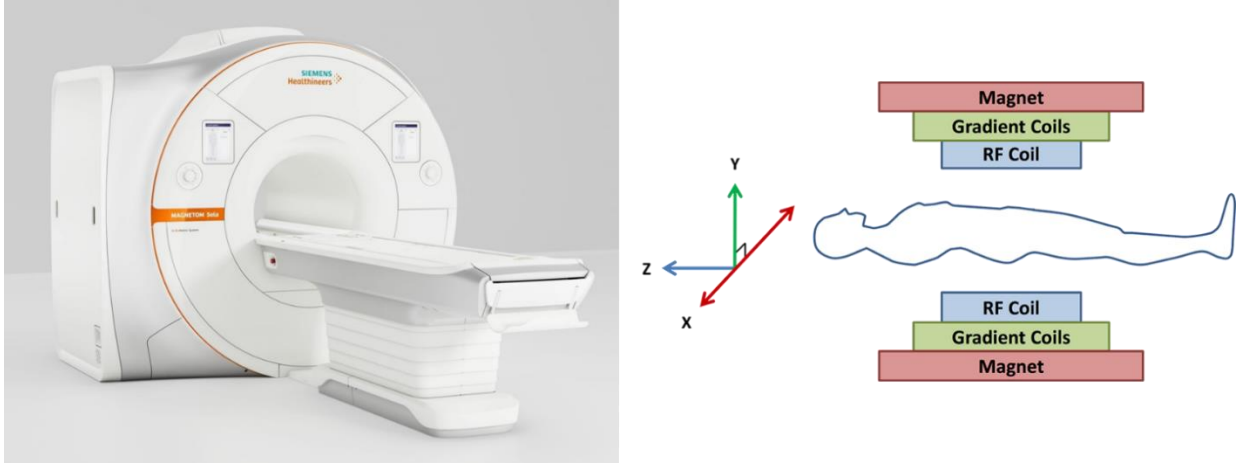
Simplified MRI system and location of coils.
